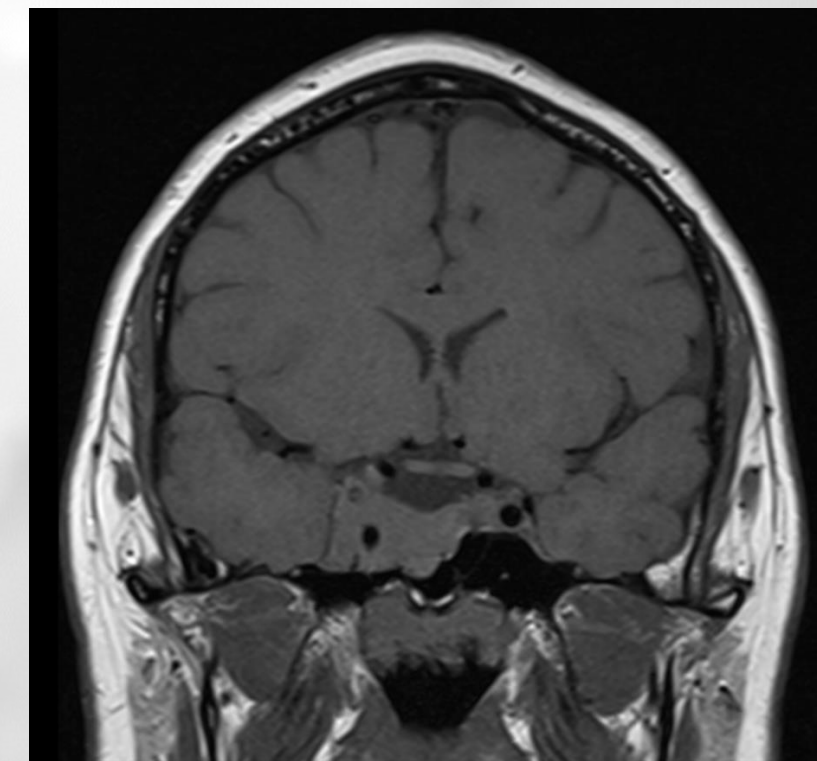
MRI Pituitary following 6 months of cabergoline treatment
